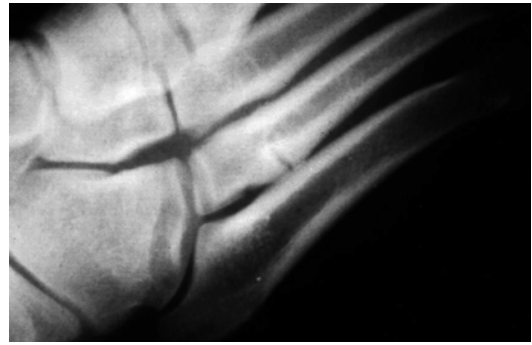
Stress fracture of the base of the 4th metatarsal, as seen on X-ray
